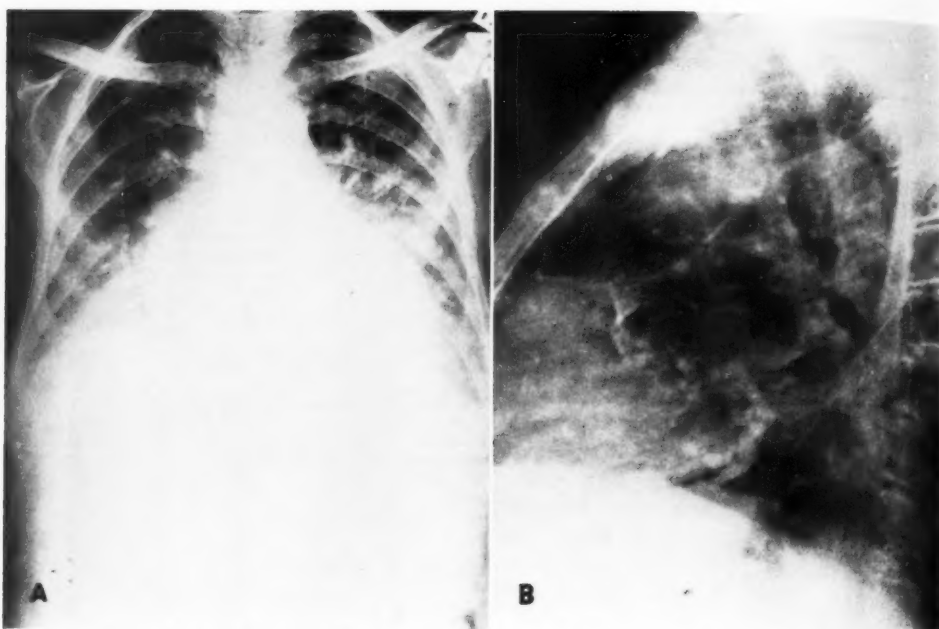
Case 4. A. Postero-anterior chest roentgenogram shows generalized cardiac enlargement with pulmonary congestion. B. Lateral chest roentgenogram shows calcification in mitral and aortic valves, with faint calcific deposits in coronary arteries. Wall of ascending aorta also calcified. Moderate degree of spondylosis deformans in dorsal spine.
